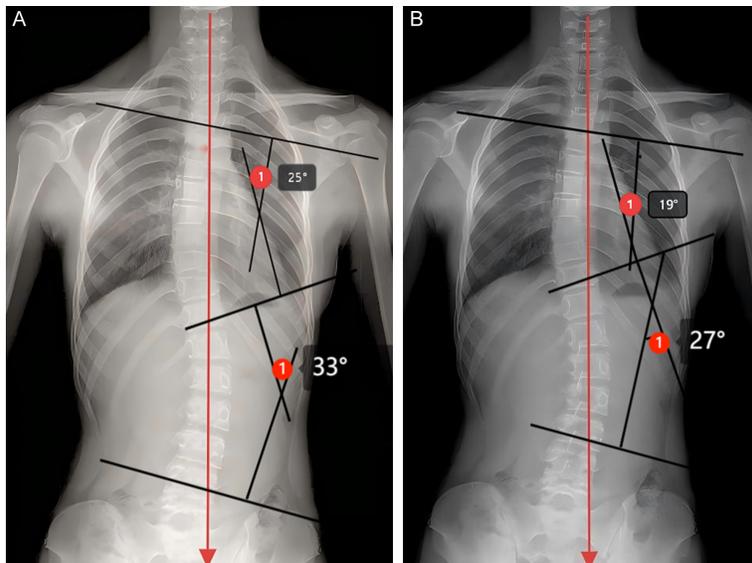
Radiographic comparison of spinal alignment before and after combined therapy. A: Pre-treatment image showing thoracolumbar S-shaped scoliosis (thoracic Cobb 25°, lumbar Cobb 33°). B: Post-treatment image showing improvement with thoracic Cobb reduced to 19° and lumbar Cobb to 27°.
